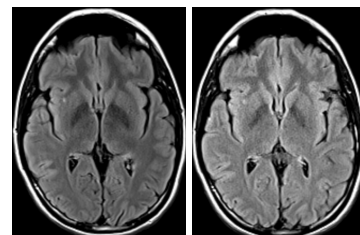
FLAIR images of a patient obtained using the 32 (left) and 12 (right) array elements coil. Grey and white matter can be better differentiated on the left image.
